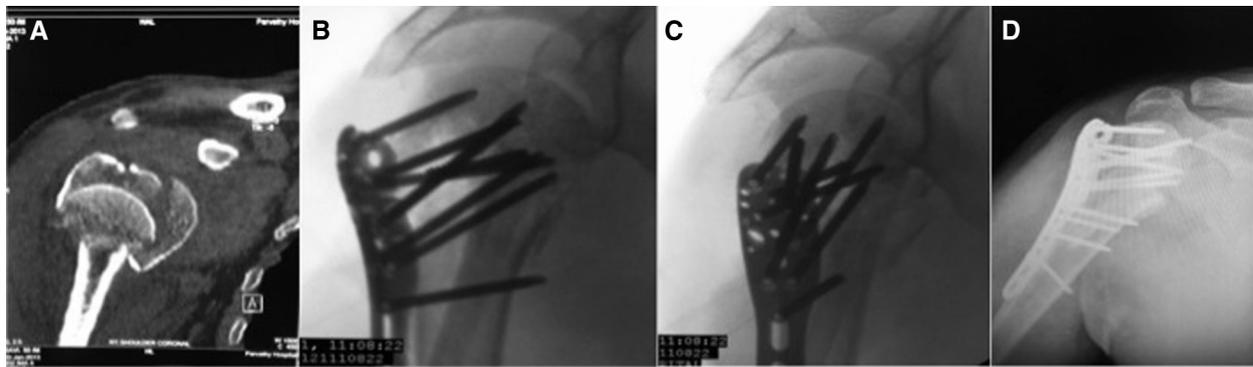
(A) Coronal CT shows a 4-part head-splitting fracture at the level of the anatomic neck. (B and C) Postoperative radiographs show satisfactory reduction. (D) At 18-month follow-up, radiograph shows avascular necrosis, collapse of the humeral head, and intra-articular screw penetration.
